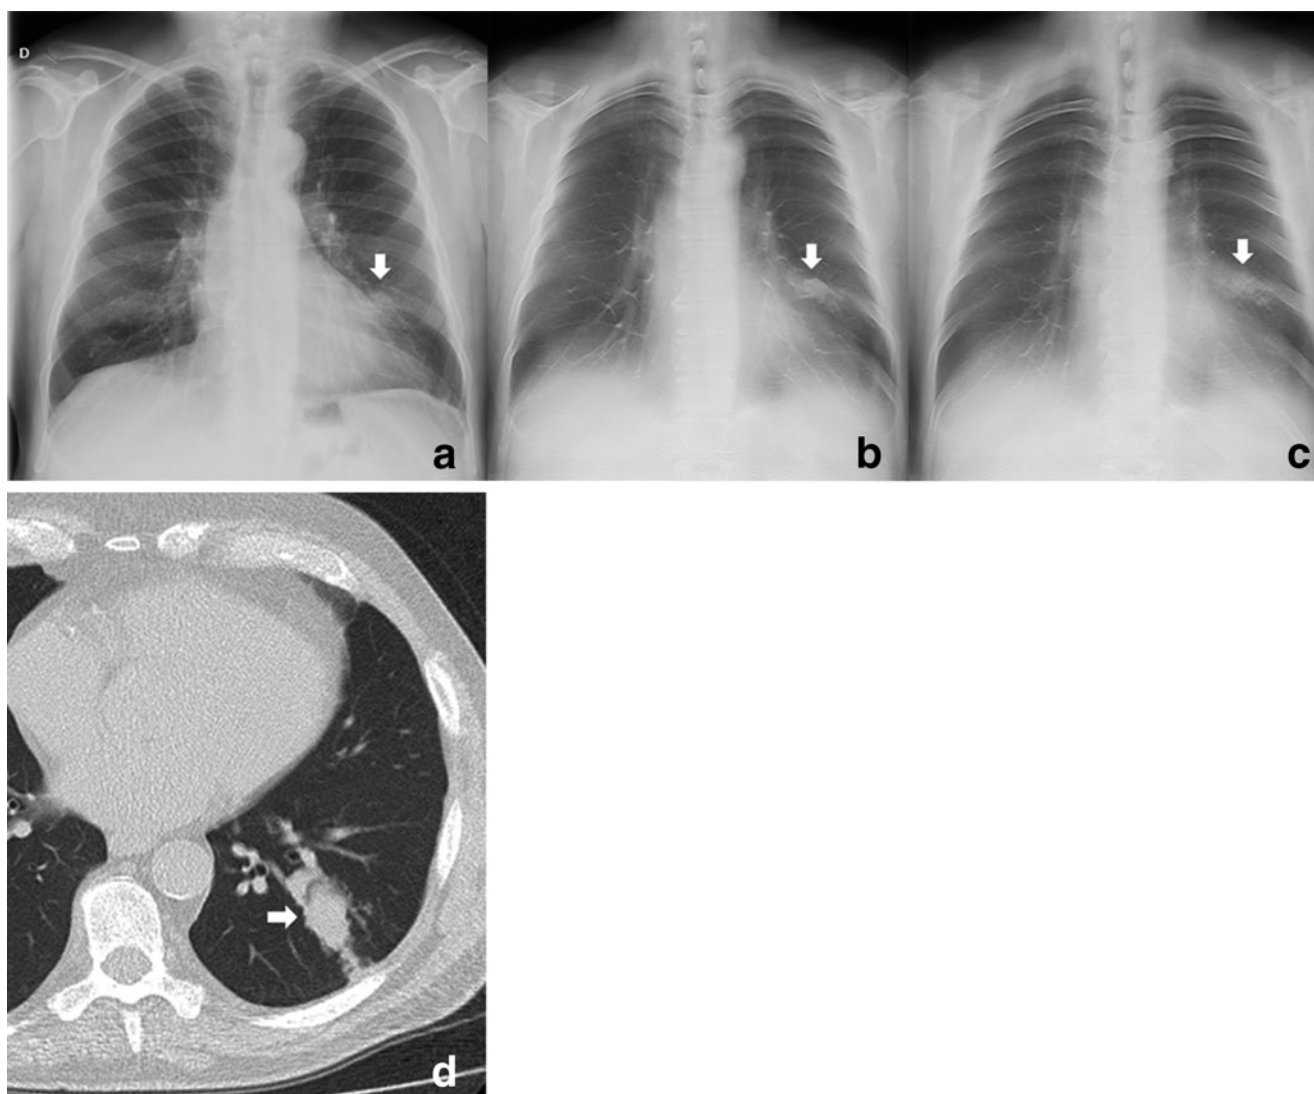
A 75-year-old man with a peripheral pulmonary opacity. a Posteroanterior chest radiography in the upright position shows suspected opacity on the left lung (arrow) near the cardiac left profile. b, c Digital tomosynthesis planes confirm the opacity (arrow) even though
